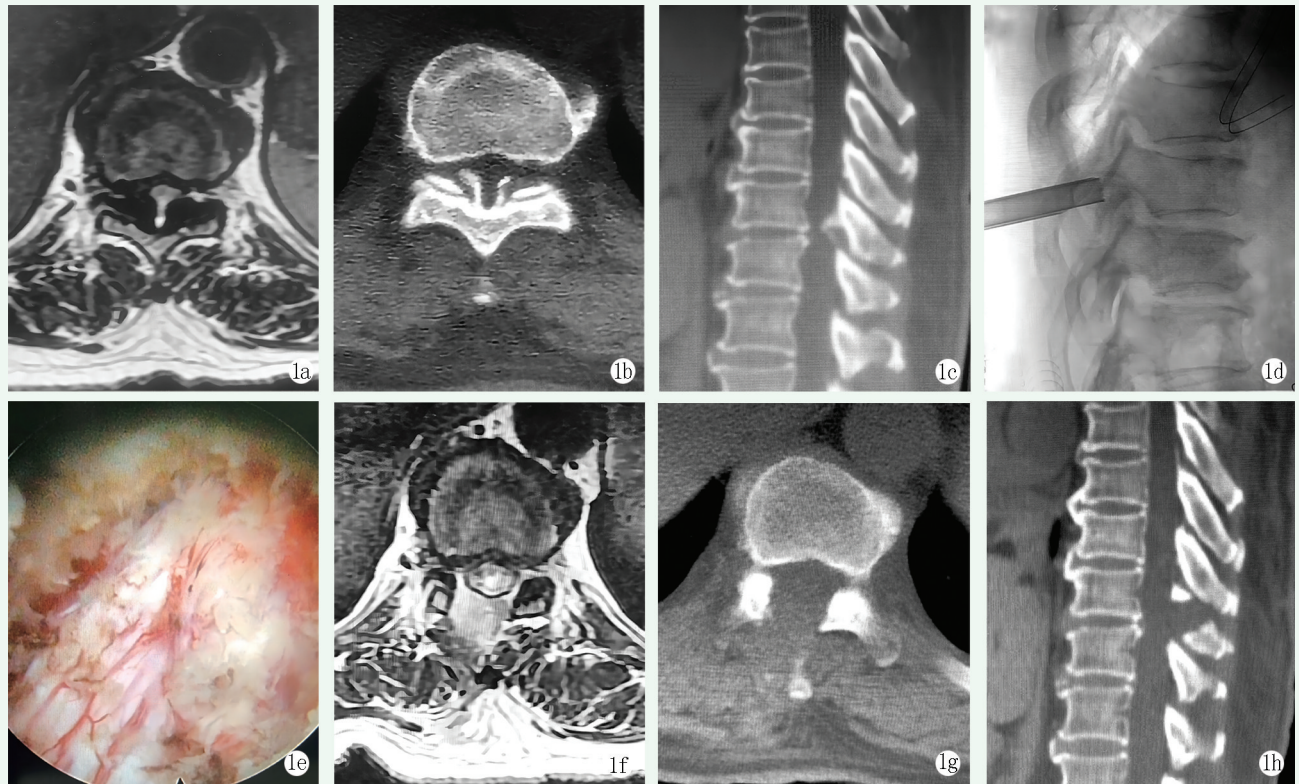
患者男性, 56 岁。1a, 1b: 术前胸椎 MRI、CT 横断位提示 T_{10/11} 黄韧带骨化, 脊髓压迫; 1c: 术前胸椎 CT 矢状位提示“鸟嘴”样骨化; 1d: 术中 C 形臂 X 线机透视下置入环锯; 1e: 术中显示骨化黄韧带彻底切除; 1f~1h: 术后复查 MRI、CT 提示骨化黄韧带切除, 硬脊膜恢复正常形态, 两侧关节突完整保留。
